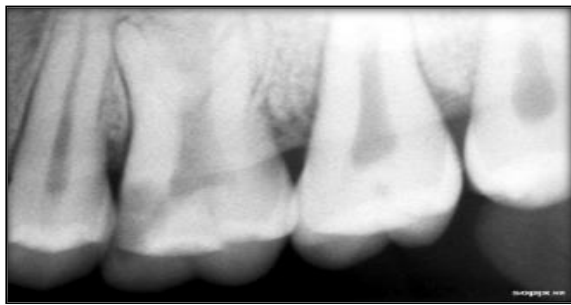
Bitewing radiograph of maxillary molar region showing mesial proximal caries (Direct Digital radiographic method)
